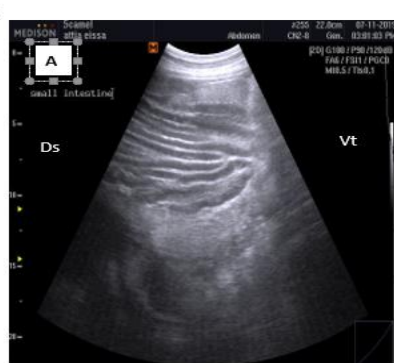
Ultrasonogram of small intestine in camel A- control group B- SI group C- RA group
